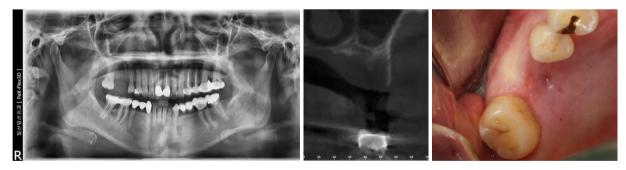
~3. Pre-operative radiograph & Intra-oral view Pre-op CT scan shows severe palatal bone defect at right 1st molar area.
